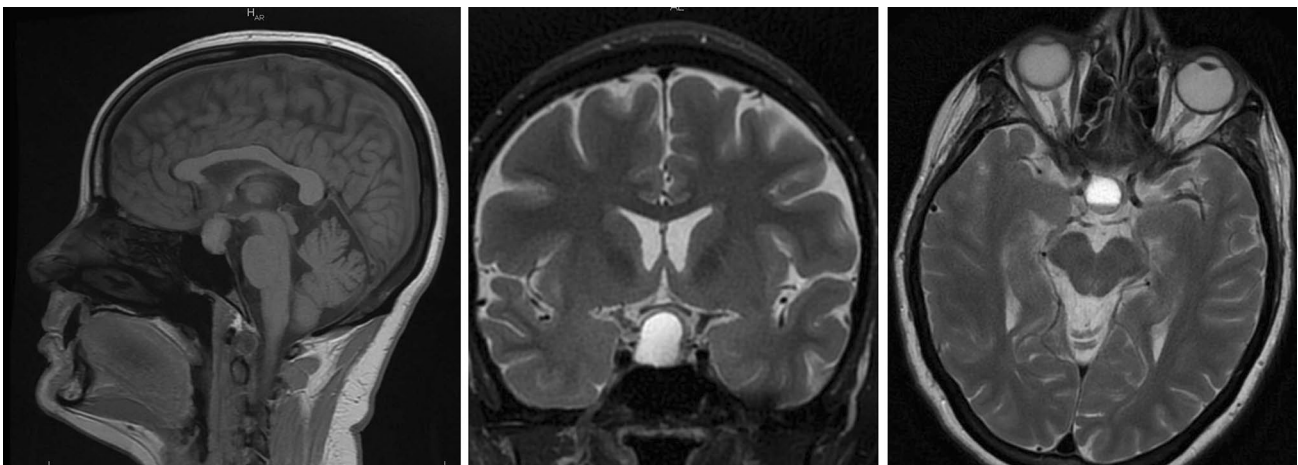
Macroprolactinoma apoplexy at 28 gestational week. The case of a 32-year-old pregnant woman (28 gestational weeks) who presented with intermittent headaches and left visual loss for 2 weeks. Regarding the left eye, visual acuity was 6/10 with an altered visual field. Visual acuity and field were normal for the right side. Prolactin was considered in the normal range for the pregnancy term (450 ng/ml). No diplopia was observed, and MRI revealed apoplexy
